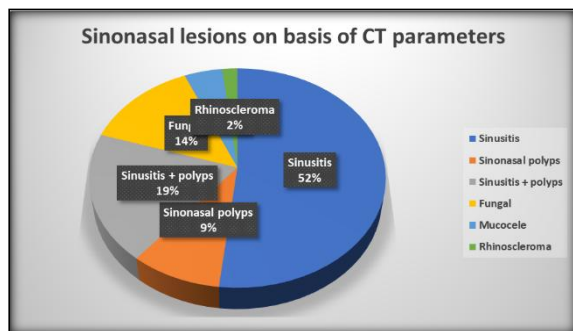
Sinonasal lesions on basis of CT parameters
